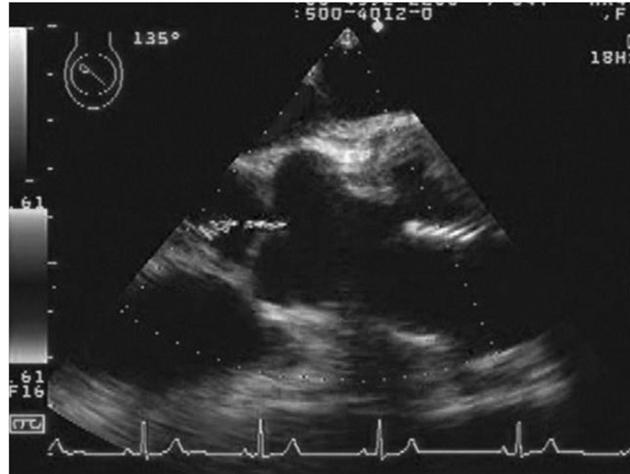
Preoperative echocardiography revealed a mild grade of aortic regurgitation.
